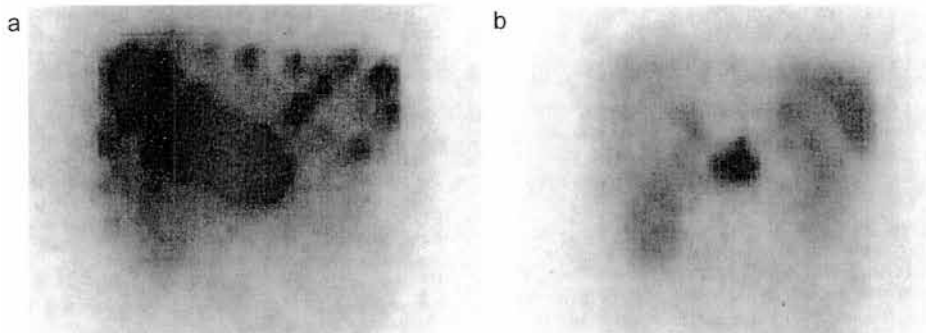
a. Planar scintigraphic scan of the abdomen 46 hours after the injection of 200 mCi ^{90}Y -DOTATOC and 3 mCi ^{111}In -DOTATOC in a patient with NET of the pancreas with liver metastases. The scan was performed after the first treatment. b. Planar scintigraphic scan of the abdomen 46 hours after the injection of 200 mCi ^{90}Y -DOTATOC and 3 mCi ^{111}In -DOTATOC in the same patient shown in Figure 1a. The scan was performed after the second treatment. Scintigraphically, a clear reduction of the primary tumor and the liver metastases can be seen.
